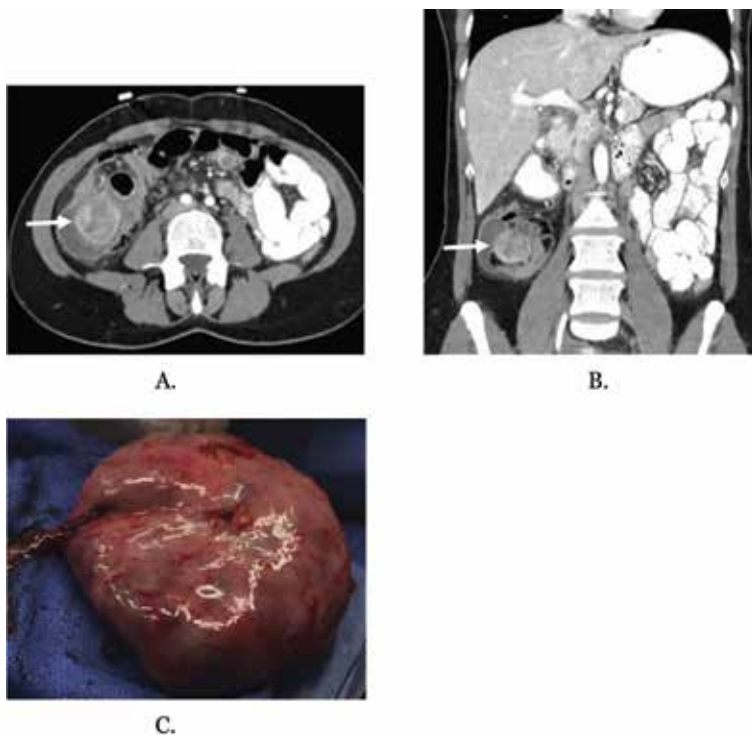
(A and B) Axial and coronal images from a contrast-enhanced CT of the abdomen and pelvis of a patient with constipation and bloody bowel movements. There is an enhancing polypoid mass that arises in the cecum and extends into the lumen. (C) The patient then underwent colonoscopy and right colectomy for resection of a colonic adenocarcinoma.
